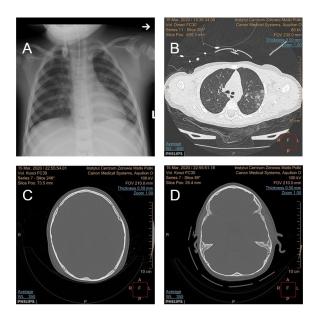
Diagnostic Imaging (day 1): A. Chest x-ray: multilobar ground-glass opacities are seen in left lung, mostly in upper to mid lobes lungs, with a peripheral subpleural distribution. Lack of pleural fluid. B. CT: Multilobar ground-glass opacities are seen in left lung, mostly in upper to mid lobes lungs, with a peripheral subpleural distribution. Lack of pleural fluid. C. CT: The fracture in the left temporal pyramid area. D. CT: The fracture fissure in the left temporal scales
